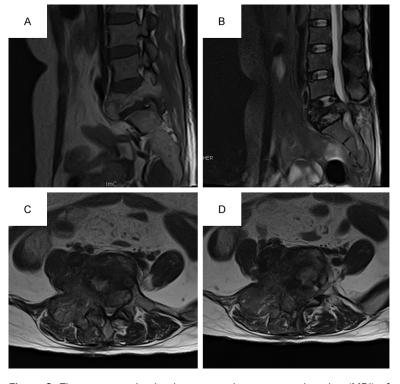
The pre-operative lumbar magnetic resonance imaging (MRI) of this patient. The pre-operative lumbar magnetic resonance imaging (A, B: Sagittal view; C, D: Axial view) showed the bone destruction of L5 vertebrae and posterior elements, the vague boundary supported the diagnosis of malignancy.
